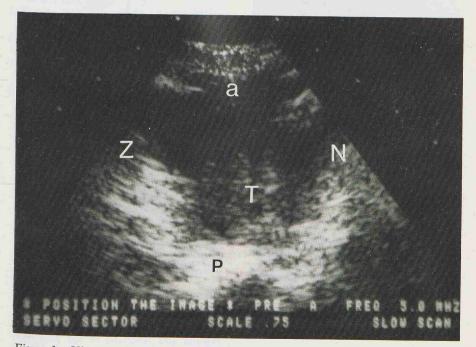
Ultrasound sector scan of a tumor in the posterior maxillary sinus. Z-zygoma, N-nose, T-tumor, a-anterior wall, p-posterior wall
